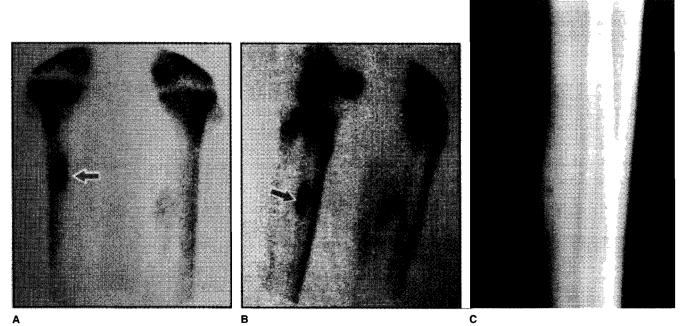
A and B, Bone scans diagnostic of a right-sided posteromedial stress fracture. C, Lateral plain film of the tibia reveals an ominous focal transverse radiolucent line (stress fracture). (A and B, From Hutchinson MR, Cahoon S, Atkins T: Chronic leg pain. Physician Sports Med 26[7]:37-46, 1998; C, from Mann RA, Coughlin MJ: Surgery of the Foot and Ankle. St. Louis, Mosby, 1999.)
